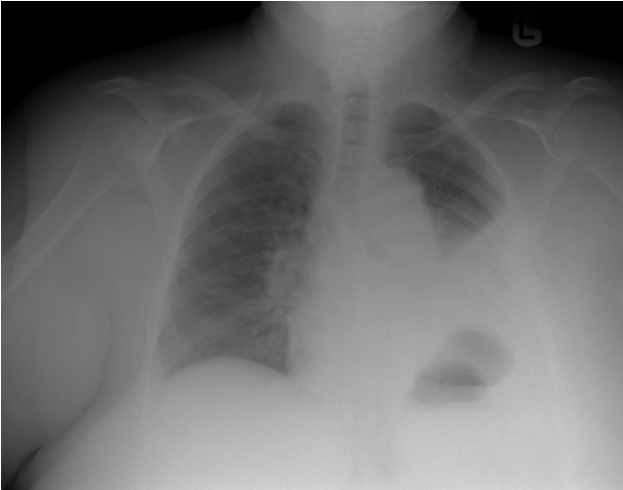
Initial chest x-ray demonstrates left-sided diaphragmatic hernia secondary to diaphragmatic rupture.
